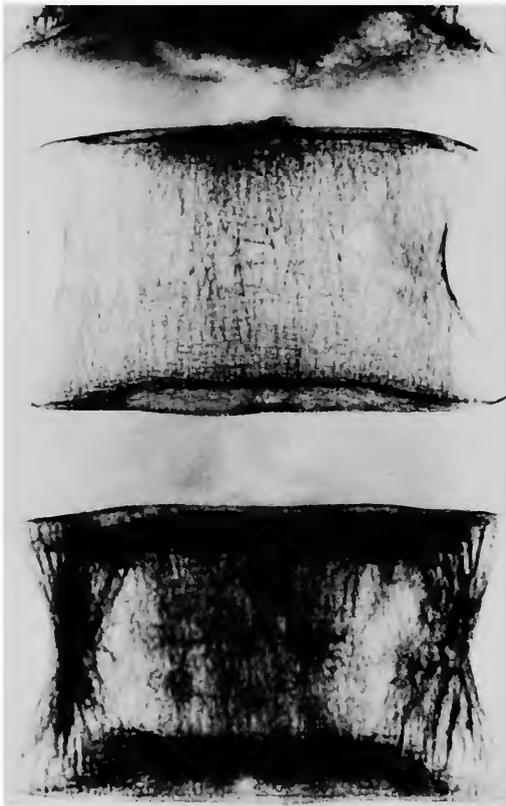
X-ray of Paget's disease of vertebra with adjacent normal vertebra (above). Note increased density and coarsening of the spongiosa of the involved vertebra. (European X-rays show densities as black and lucencies, white; studied by Putschar.)
